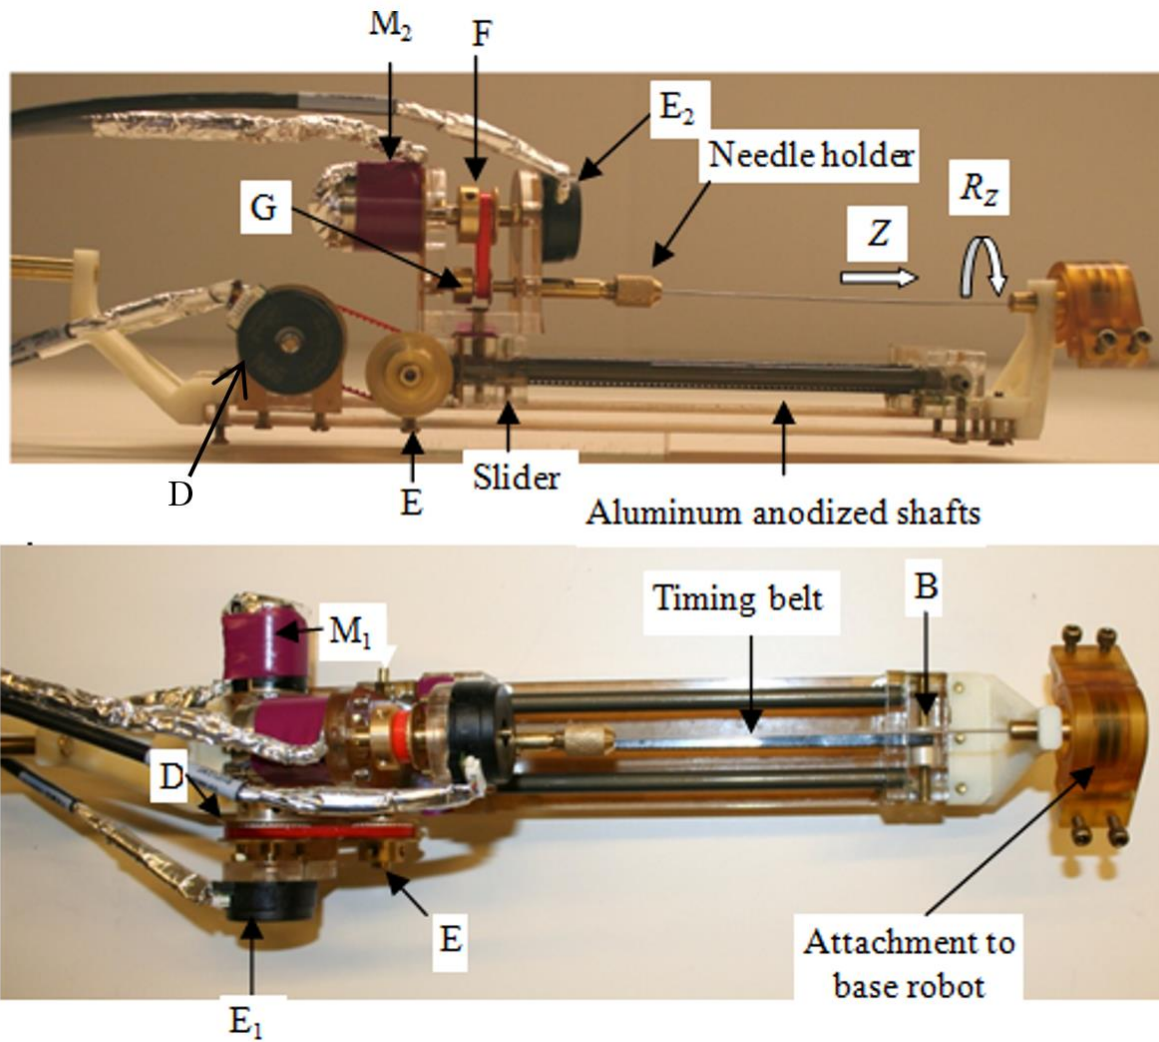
MRI-compatible needle steering slave robot with 2-DOF: translation along Z (superior-inferior) and rotation of the bevel-tip needle  $R_z$ . Cables are shielded carefully.
